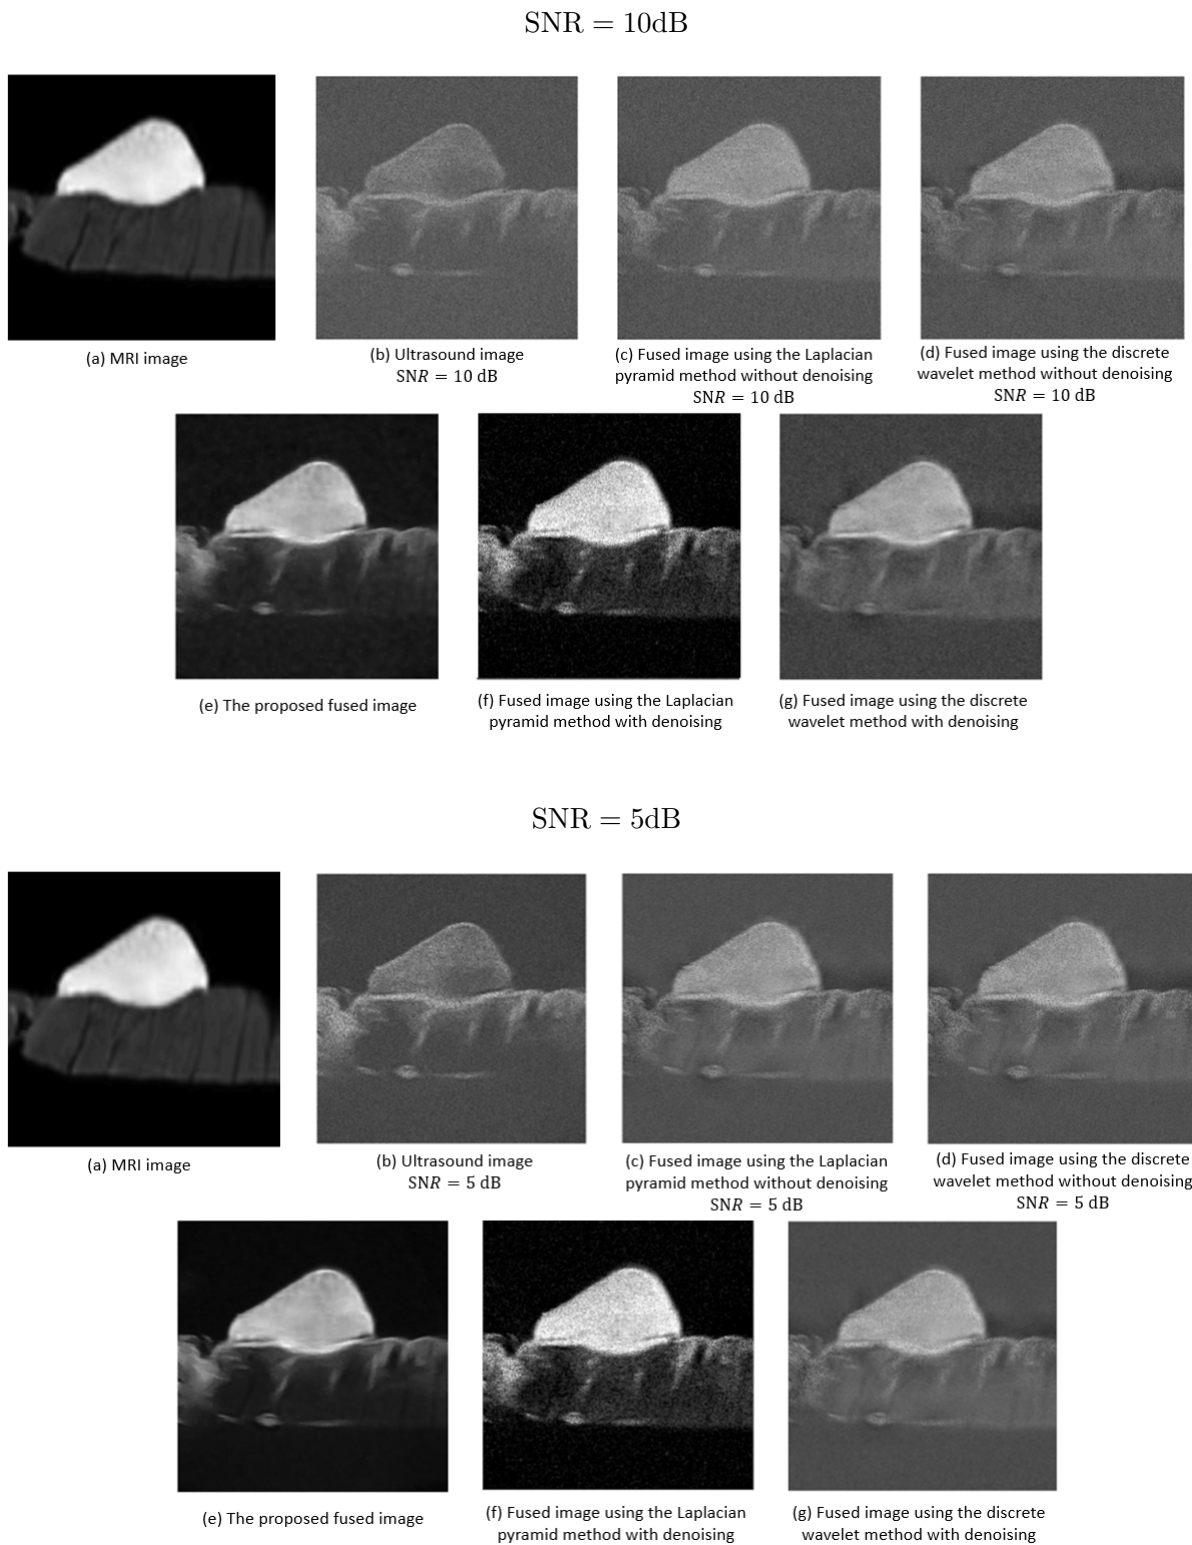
Influence of SNR of the ultrasound image on the fused images, (a) and (b) are the MRI and US images, (c) and (d) show the fused images using the Laplacian pyramid and the discrete wavelet methods without denoising the US image, (e) shows the fused image using the proposed method, (f) and (g) show the fused images using the Multi-scale Laplacian pyramid and the discrete wavelet methods after denoising the US image.
